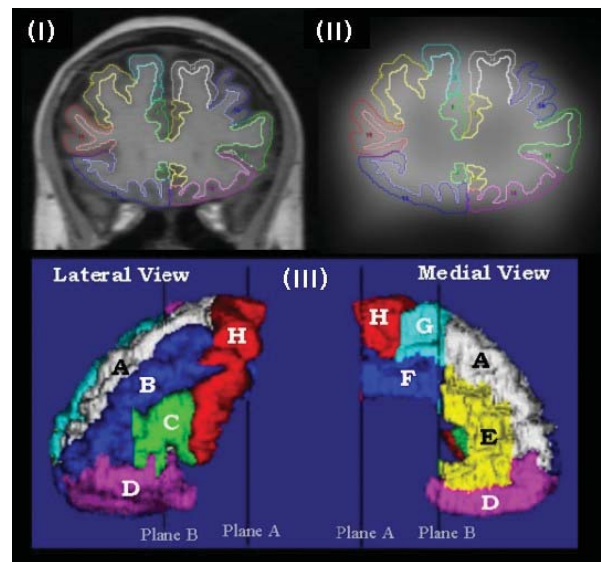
The frontal subregions traced on the magnetic resonance image (I) and applied to the registered image obtained with positron emission tomography (II). The 3D reconstructed frontal substructures displayed on the three different views (III); the regions consist of the superior frontal gyrus (A), the middle frontal gyrus (B), the inferior frontal gyrus (C), the orbitofrontal cortex (D), the rostral portion of the anterior cingulate (E), the caudal portion of the anterior cingulate (F), the supplementary motor area (G), and the precentral gyrus (H). Planes A and B indicate the artificial coronal planes, which are the posterior boundary of the medial portion of the frontal lobe in the case of plane A, and the anterior boundary of the supplementary motor area and caudal portion of the anterior cingulate, in the case of plane B
